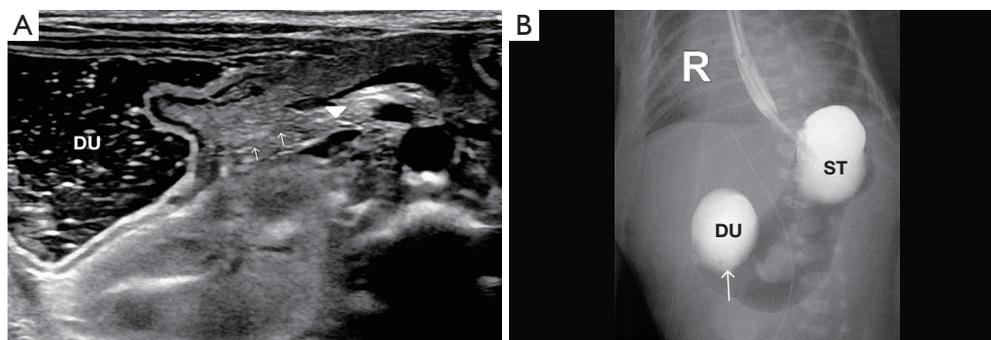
A patient with duodenal atresia. (A) Postnatal ultrasonography demonstrating a dilated duodenum terminating in a blind pouch, which is not connected to the horizontal segment of the duodenum (arrowhead). Additionally, hypoechoic striated structures can be observed between these two segments (arrows). (B) Upper gastrointestinal series showing a dilated stomach and duodenum located proximal to the atretic segment (arrow). DU, duodenum; ST, stomach; R, right side.
